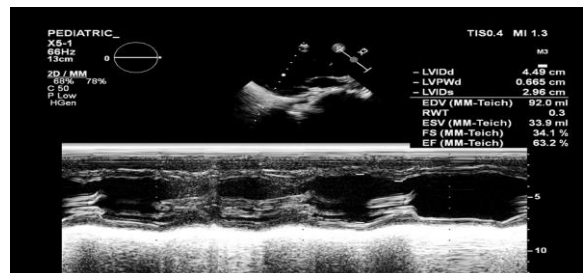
Echocardiography post catheter ablation, ejection fraction 63,2%
